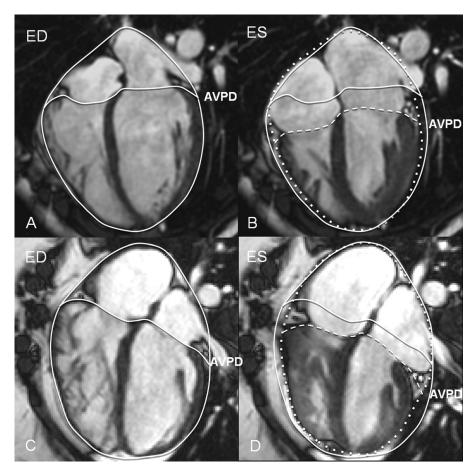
Cardiac MR images in the 4-chamber view showing outer total heart volume variations in a healthy volunteer (top row) and a patient with severe PR secondary to tetralogy of Fallot (bottom row). The outer volume variations were larger in patients with PR compared with healthy volunteers. The solid and the dotted white lines represent the pericardial contours in ED and ES, respectively. Atrioventricular plane displacement (AVPD) is seen as a solid white line in ED and a dotted white line in ES. The AVPD of the LV is similar in the patient and the healthy subject, but AVPD of the RV is smaller in the patient than the healthy subjects.
